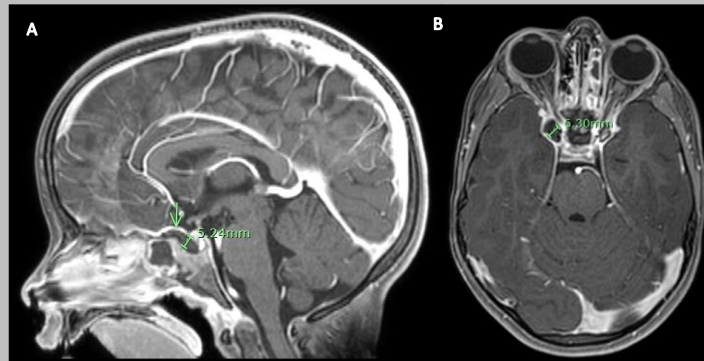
MRI Brain with and without contrast demonstrating epidural abscesses. (A) The sagittal T1 image shows a rim-enhancing collection, measuring 5.24mm, along superior right aspect of the basisphenoid bone that involves the sella and displaces the anterior pituitary. (B) The post-gadolinium axial T1 image shows a second rim-enhancing collection, measuring 6.3mm, between the anterior medial right temporal lobe and right optic nerve foramina.
